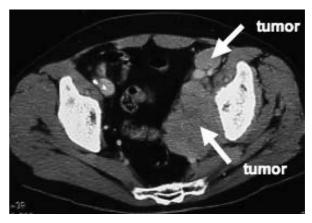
Abdominal computed tomography scan with contrast medium on admission showing a large mass with a size of 5 × 8 cm in the left side of the pelvis, which compressed the left femoral vein, but no intravenous thrombus was found
